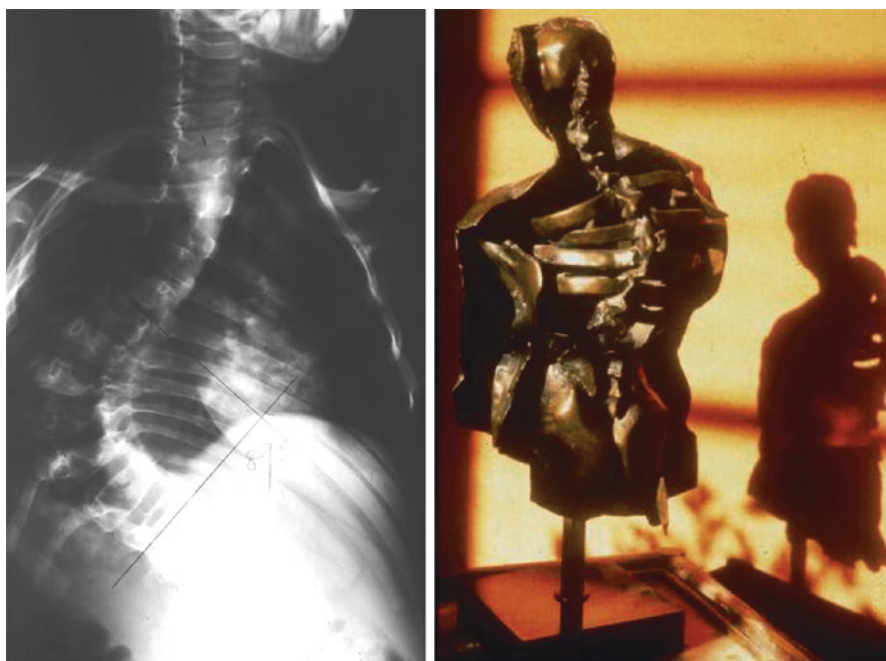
X-rays are shadows from the projection of a 3D object onto one plane
